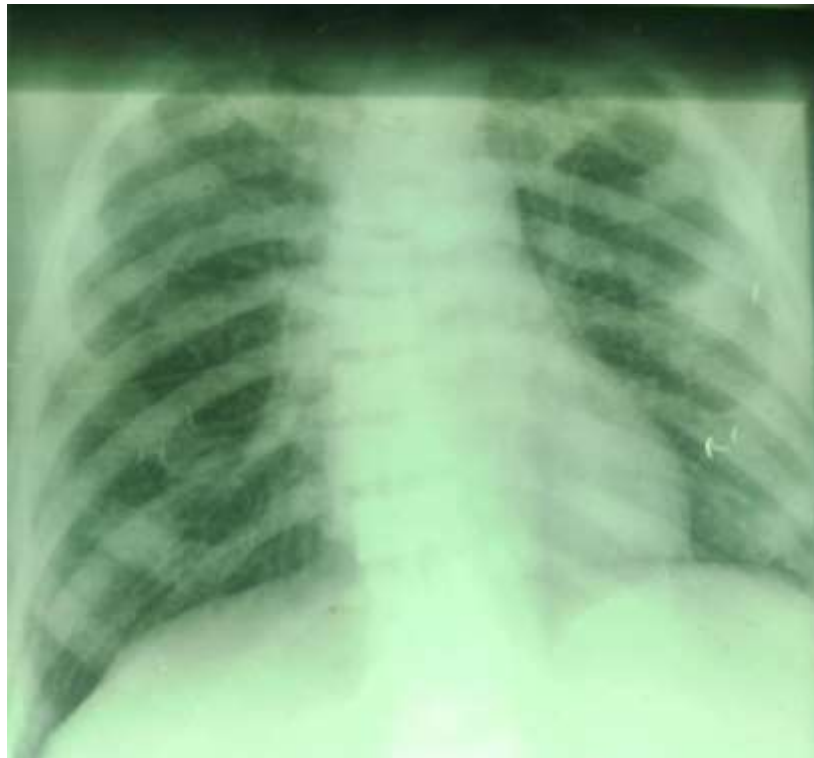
A plain chest radiograph demonstrating osteosclerosis involving all the depicted bones, gentle scoliosis is also demonstrated. The lung fields show streaky opacities with cystic lung changes bilaterally most likely from chronic bronchitis. No pulmonary nodules demonstrated. No obvious fracture seen to involve the bony thorax demonstrated.
